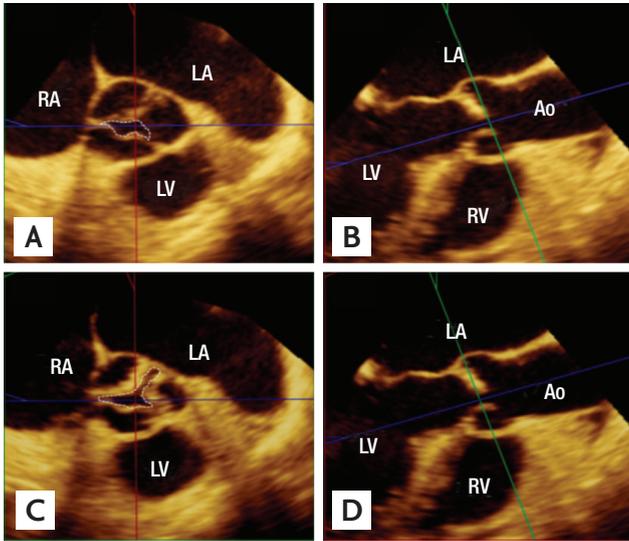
The measurement of aortic valve area by three-dimensional transesophageal echocardiography. (A, B) The tip of the aortic valve was obtained as the smallest possible area. (C, D) The shape and area of the aortic valve changed in a trivial different plane from the tip. The dotted lines indicate aortic valve area at each level. Ao, aorta; LA, left atrium; LV, left ventricle; RA, right atrium.
